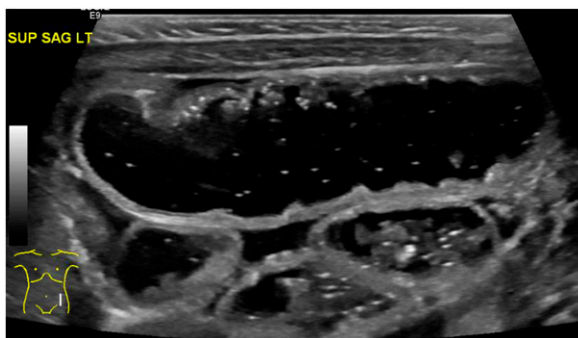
Dilated bowel loops with liquid stools on abdominal ultrasonography.
